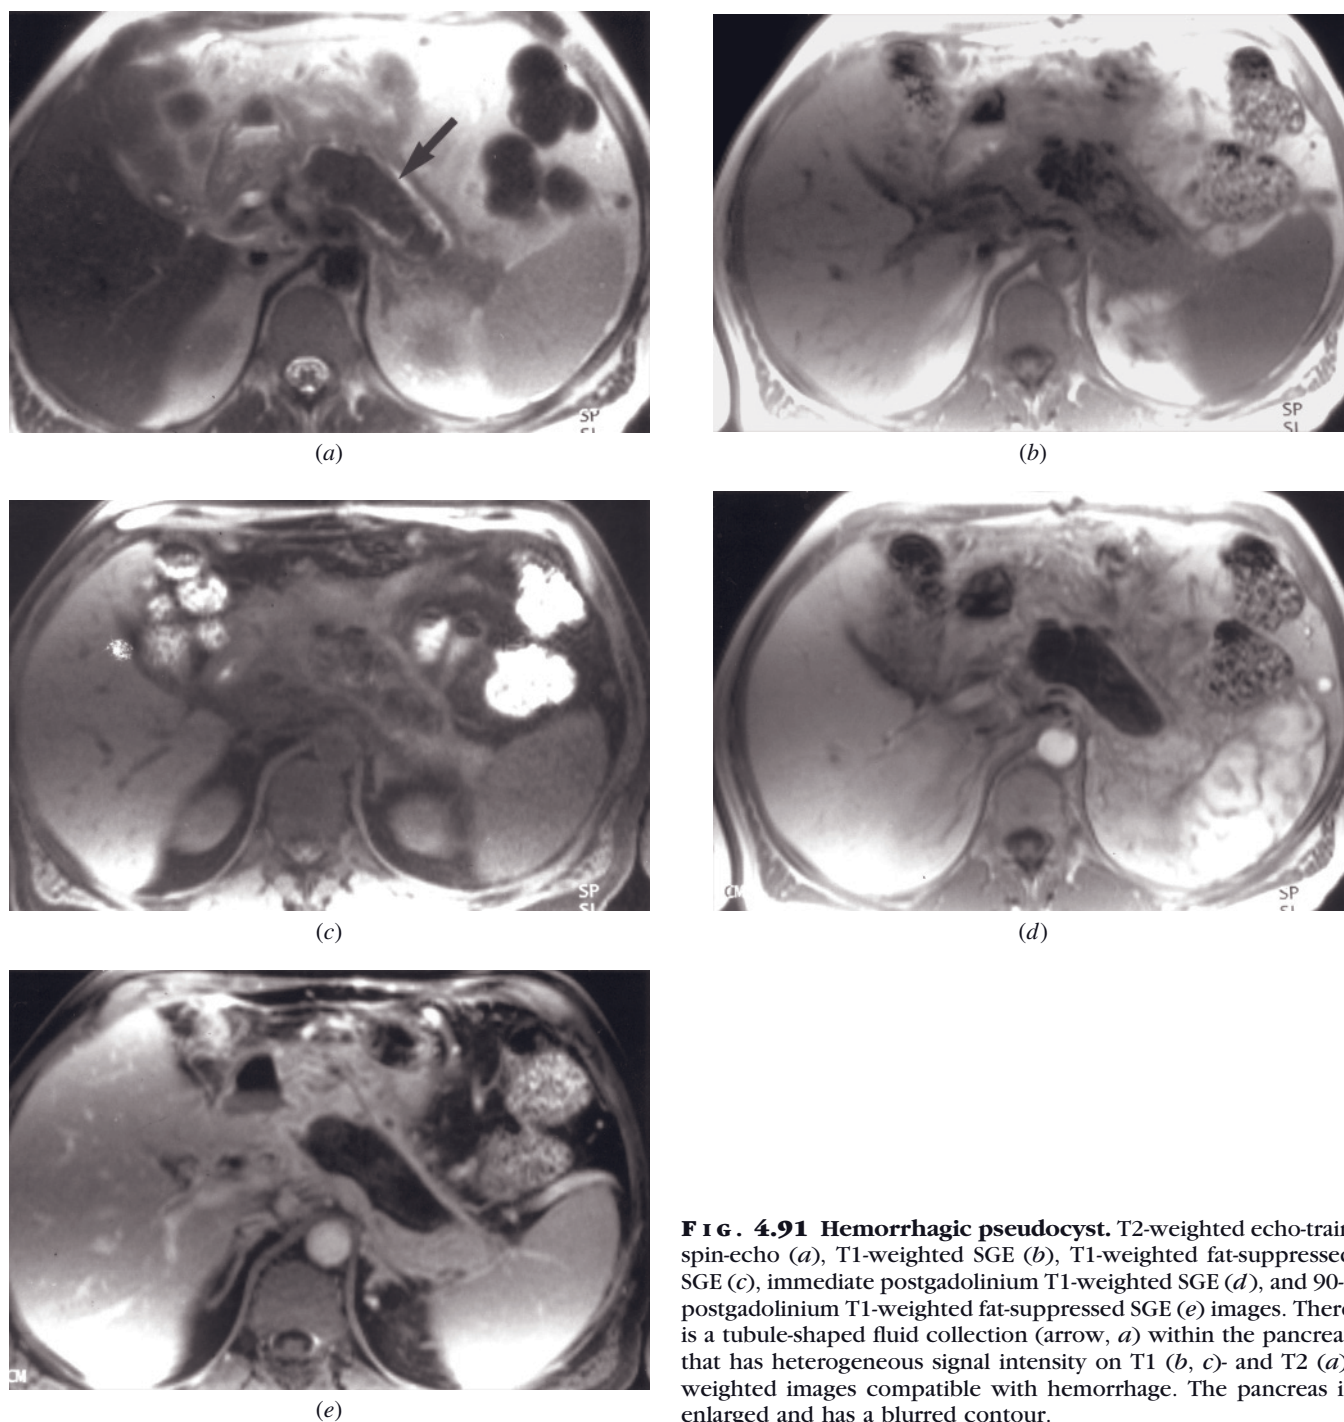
Hemorrhagic pseudocyst. T2-weighted echo-train spin-echo (*a*), T1-weighted SGE (*b*), T1-weighted fat-suppressed SGE (*c*), immediate postgadolinium T1-weighted SGE (*d*), and 90-s postgadolinium T1-weighted fat-suppressed SGE (*e*) images. There is a tubule-shaped fluid collection (arrow, *a*) within the pancreas that has heterogeneous signal intensity on T1 (*b*, *c*) and T2 (*a*) weighted images compatible with hemorrhage. The pancreas is enlarged and has a blurred contour.
